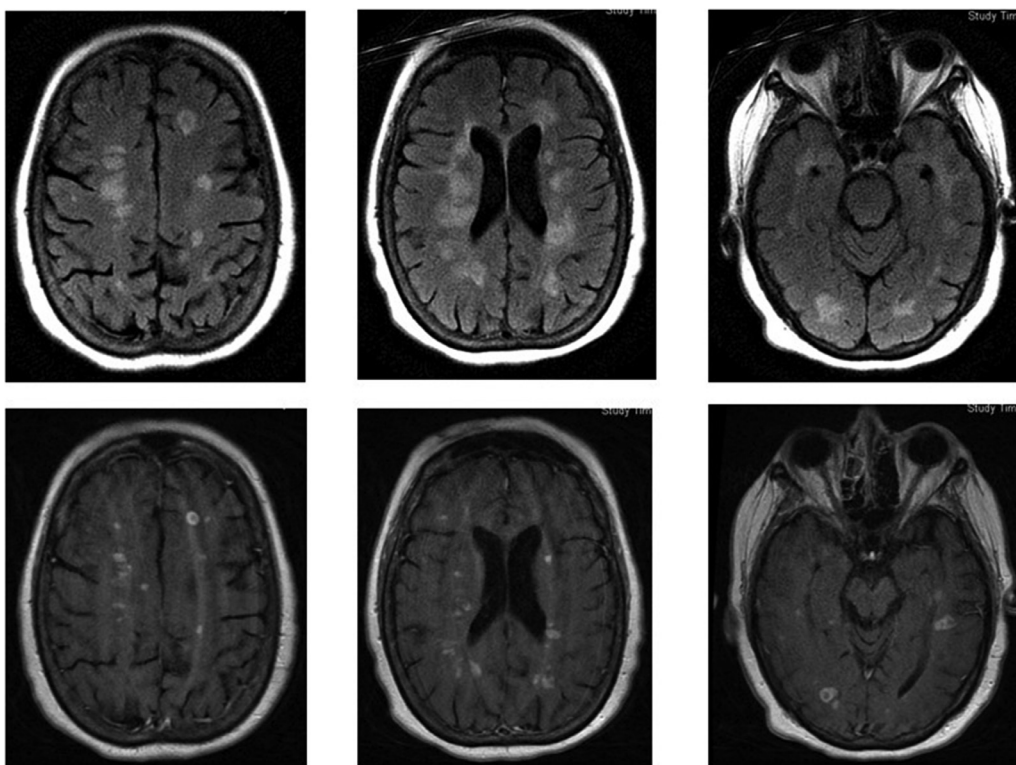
Top row: MRI Brain FLAIR sequences from second presentation, ten years later. Bottom row: corresponding MRI brain postcontrast imaging with multiple enhancing white matter lesions in both cerebral hemispheres involving the deep and subcortical white matter. The white matter abnormalities have worsened since the previous exam and contrast enhancement is new.
